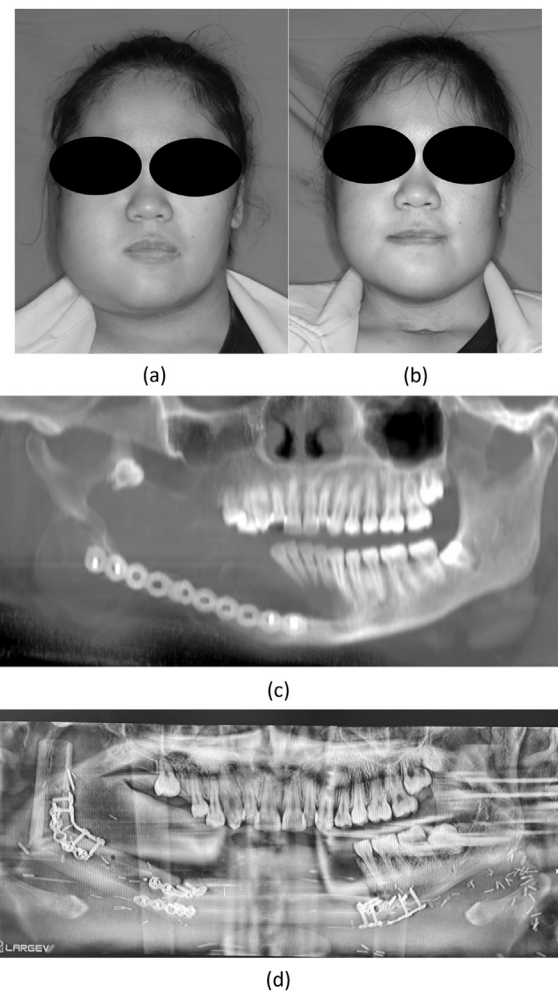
Clinical photos (case 1). (a)Pre-operative facial appearance. (b)1-month post-operative facial appearance. (c)Pre-operative orthopantomogram. (d)1-month post-operative orthopantomogram.
